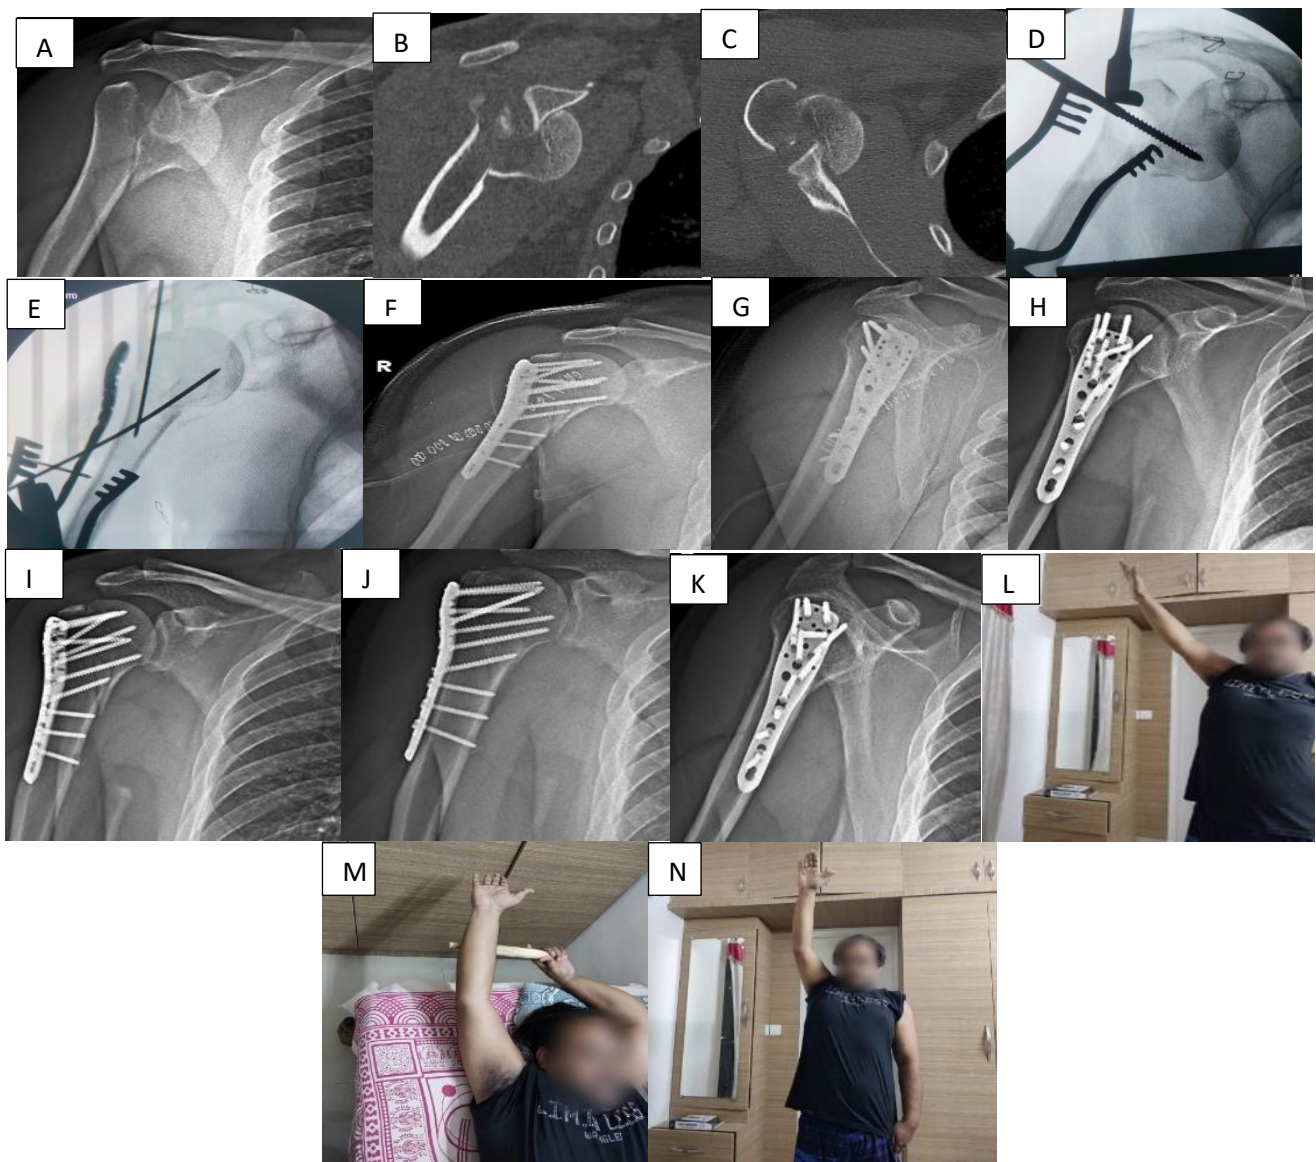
(A-C) 32-year-old patient's pre op X-ray and CT showing proximal humerus fracture dislocation (Neer's 3 part), (D and E) Intra op c-arm images-Reducing the head with steinmann pin and holding with k wires, (F and G) Immediate post op X-rays, (H and I) X-rays after 1 month. (J and K) X-rays after 1 year showing good bony union, (L-N) Patient showing good range of motion at the end of 1 year with CMS score of 81.
